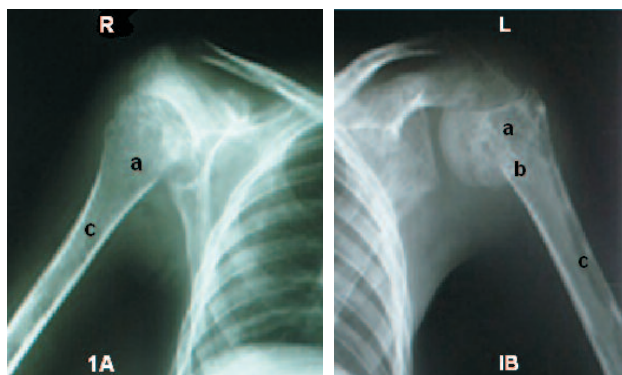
and 1B: Plain X-ray of shoulder region (Rt and Lt)
